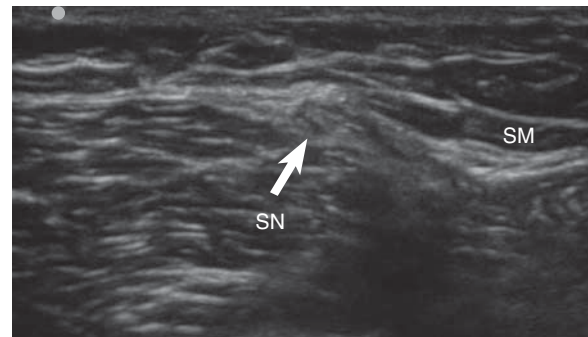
Ultrasound scan of the saphenous nerve (SN) below the sartorius muscle (SM).
